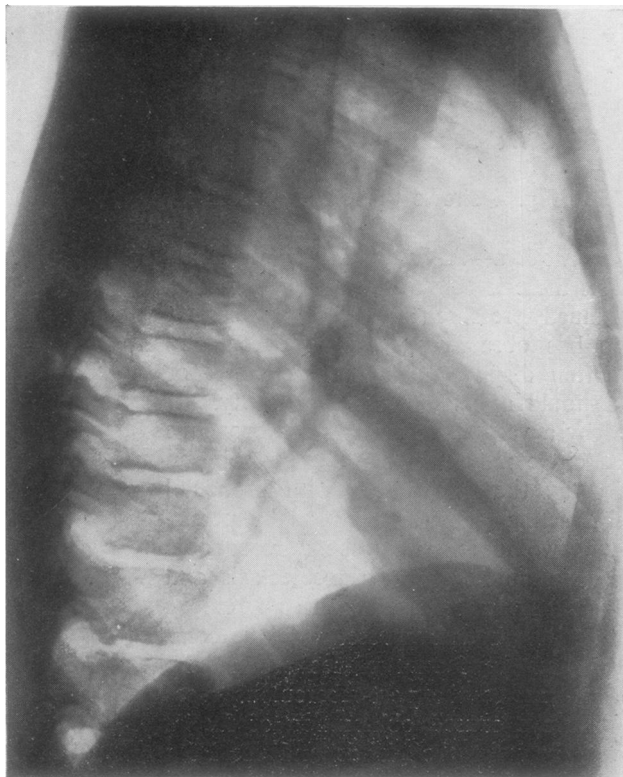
Plain lateral radiograph showing narrow opacity due to a collapsed middle lobe. A calcified primary focus is seen in the adjacent part of the lower lobe, and two large calcified glands can be seen in relation to the hilar portions of the middle lobe.
